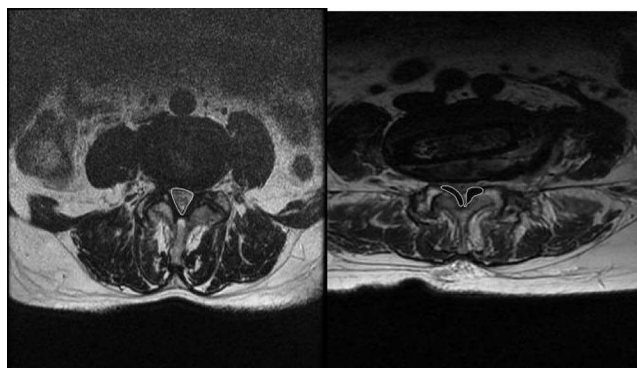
The cross-sectional areas of the spinal canal and ligamentum flavum were measured on T2-weighted MRI.
